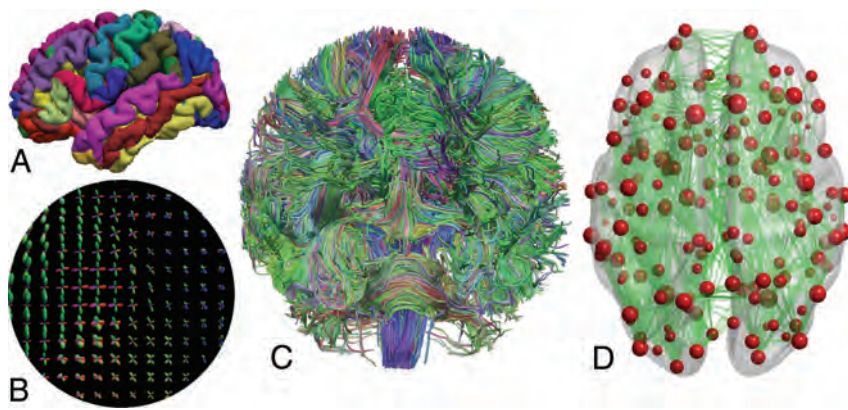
Reconstruction of structural brain connectivity networks. A, Cortical and subcortical GM was parcellated into 164 regions based on the T1-weighted images. B, Constrained spherical deconvolution was used to estimate complex fiber orientation distributions from diffusion MR imaging data. C, Whole-brain probabilistic streamline tractography was performed to reconstruct (D) structural brain connectivity networks, in which nodes represent GM regions and the edges between the nodes represent the WM connectivity (number of streamlines) between the regions. The size of the nodes corresponds to the strength of the node, and the opacity of the edges is scaled according to the number of streamlines. The fiber orientation distributions and whole-brain tractography are colored according to the directions in the brain: red (left-right), blue (superior-inferior), and green (anterior-posterior).
